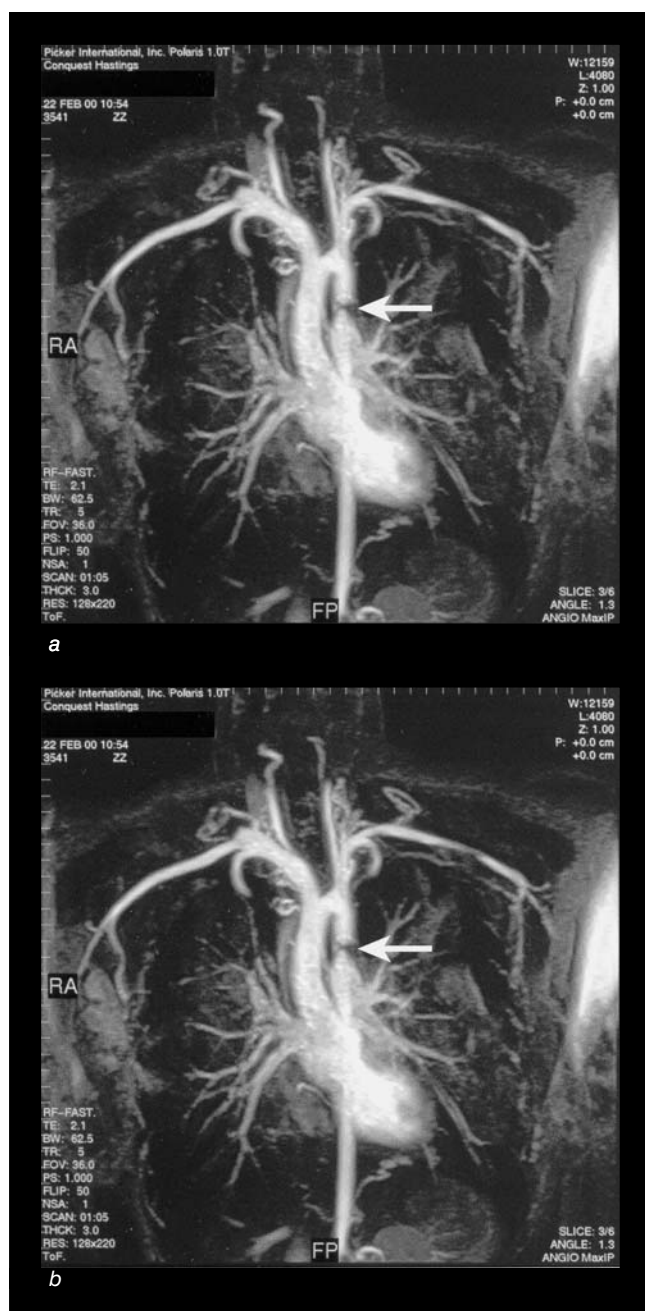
MRI of the thoracic aorta, demonstrating coarctation of the descending thoracic aorta (see arrow). ^aAntero-posterior projection. ^bLateral projection.
